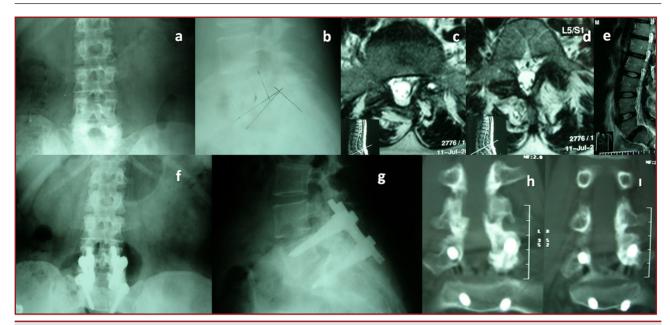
a-1. A 44-year-old female patient had referred to our outpatient clinic with a 3-year back pain, which was alleviated painkillers and exacerbated with leaning. Except for a claudication at about 20 meters, the patient was neurologically intact. The patient received medication and physical therapy rehabilitation during preoperative period but her pain did not relieve. MRI, CT and x-rays were confirmed diagnosis of L_5 - S_1 spondylolisthesis. Total L_5 laminectomy and insertion of bilateral transpedicular screw-rod posterior instrumentation were applied. The screws placement was control with performing x-rays on postoperative first day. The patient was discharged after relieve her symptoms. Postoperative 4th year lumbar CT showed that fusion developed.
